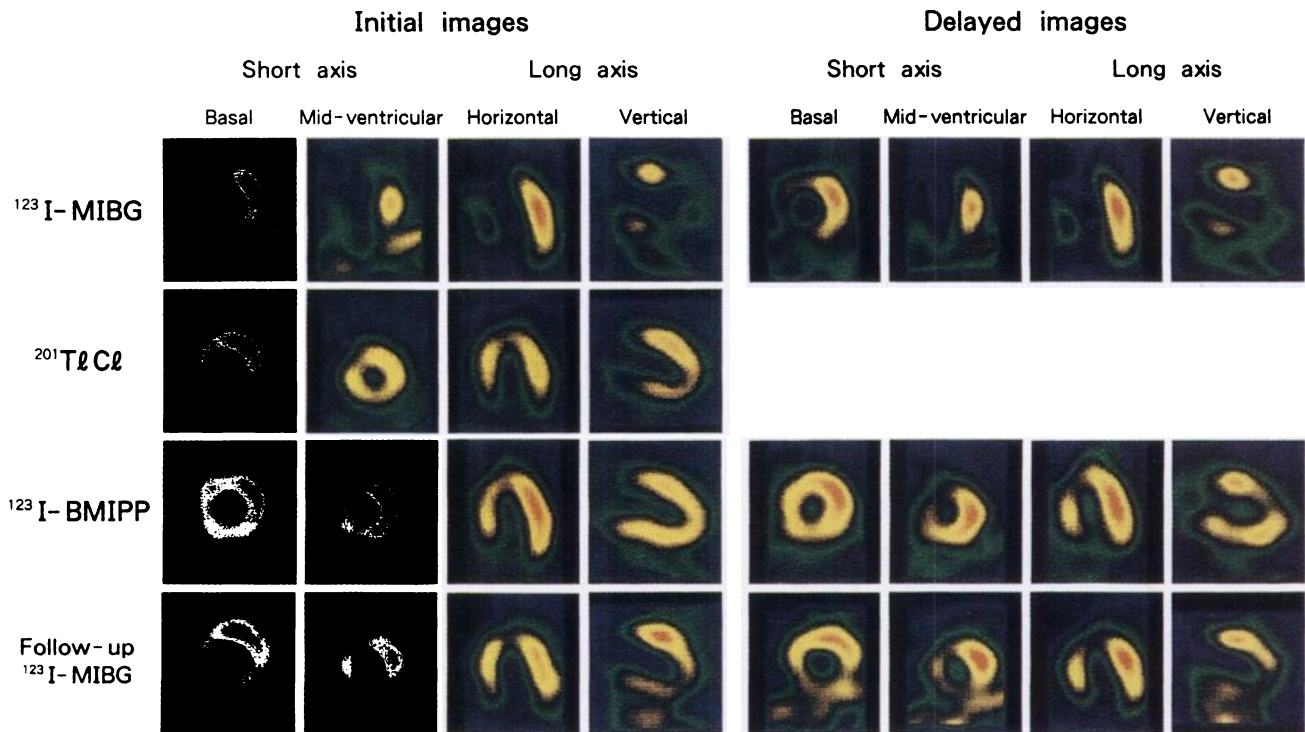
Iodine-123-MIBG myocardial SPECT image reveals marked denervation in the anteroseptal and inferoposterior myocardium; the ²⁰¹Tl image was nearly normal. Iodine-123-BMIPP image shows relatively lower tracer uptake in the anteroseptal region than in other regions. Follow-up [¹²³I]MIBG SPECT reveals reinnervation in the same area where denervation was found in the first study.
